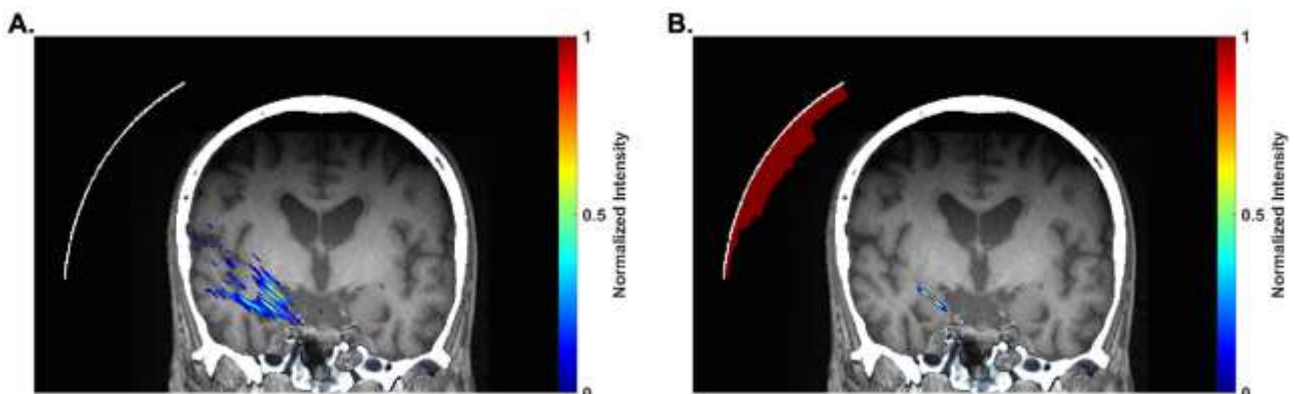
Acoustic intensity map when targeting the right amygdala without (A.) and with (B.) the use of a 3D printed acoustic lens (in dark red) covering a single-element ultrasonic transducer (in white). Sagittal planes are represented. The thickness of the lens was calculated based on a CT scan of the skull
